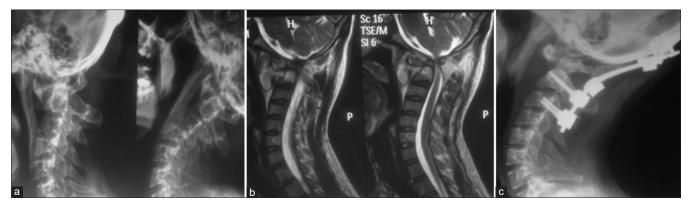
(a) Showing anteroposterior and lateral X-ray of a patient with tubercular occipitocervical instability with eroded C1–C2 lateral mass. (b) Showing magnetic resonance imaging scans with cord compression. (c) Showing postoperative X-ray with occipitocervical fusion
